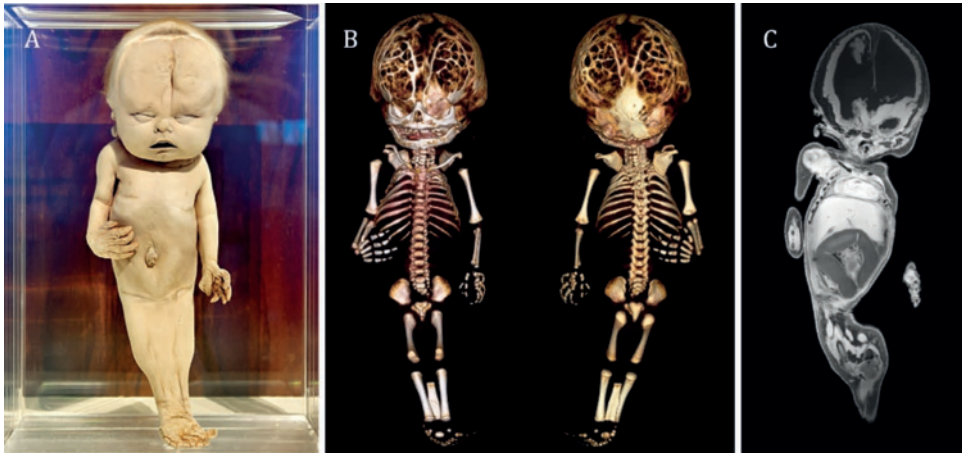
[A] Photograph of the full term fetus. [B] Three-dimensional reconstructed skeletons based on the CT data showed an extensive hydrocephaly, multiple block-, hemi- and butterfly vertebrae in the cervical and thoracic region, fused ribs, cervical ribs and absence of the seventh cervical vertebra. The second and third sacral vertebrae were fused and the fourth and fifth sacral vertebrae were hypoplastic and dorsally oriented. The coccygeal vertebrae were completely absent. The left hand showed pre-axial polydactyly. The pelvic and lower limb region of the body showed the distinctive features of sirenomelia. Note: left reconstruction depicts a frontal view, the right reconstruction depicts a dorsal view. The partially translucent appearance of the skull is a digital artifact that arise at a certain threshold value that is used during three-dimensional reconstruction of CT data. [C] T1 weighted coronal MRI image showed an extensive hydrocephalus with an absent septum pellucidum and absent corpus callosum. A malrotation of the intestines with a blind ending dilated and elongated sigmoid was seen. The internal and external urogenital characteristics were completely absent. Moreover, a double superior vena cava, a large ventricular septal defect and a single right umbilical artery that inserted high in the abdominal aorta were detected.
